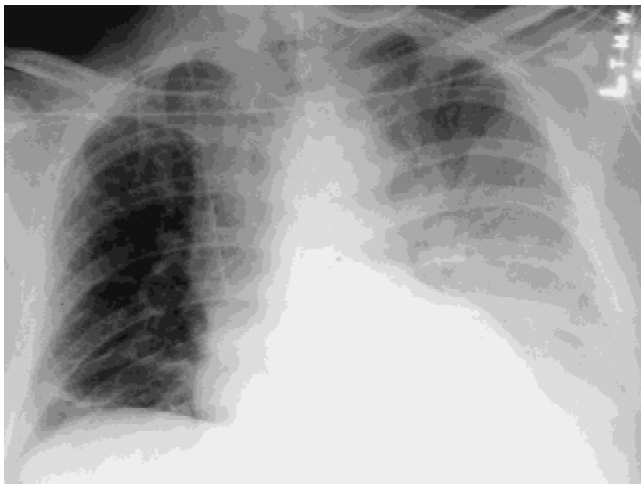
Day 3 in a patient with colon cancer and peritoneal carcinomatosis after intraperitoneal heated chemotherapy (IPHC); plain chest radiograph shows opacity in the left middle and lower lung, consistent with moderate pleural effusion and possibly associated with atelectasis. Some small densities appear at the left lower lung, indicating atelectasis.
